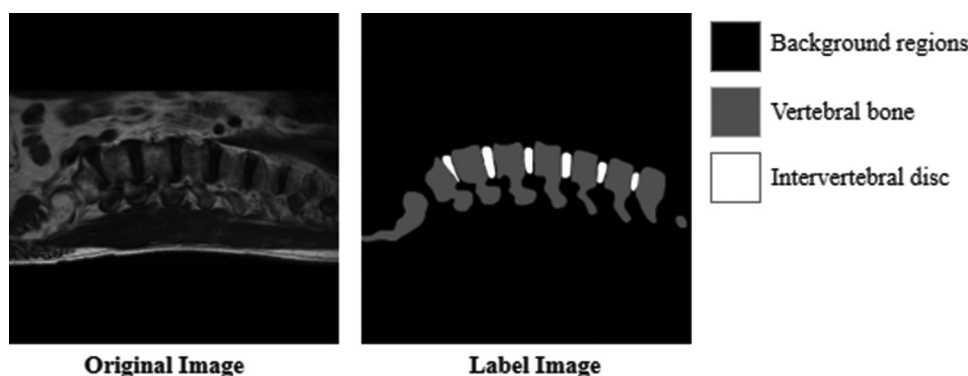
Example original spinal magnetic resonance imaging image and its corresponding label image
